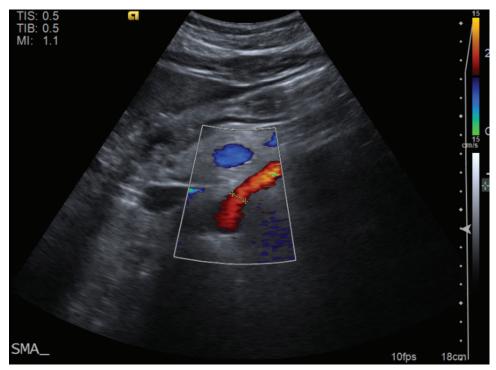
Follow-up ultrasound imaging of the same view of the superior mesenteric artery as figure 1. No dissection flap or thrombus is present. Superior mesenteric artery caliber measures 5.8-millimeters (*yellow ruler*).
